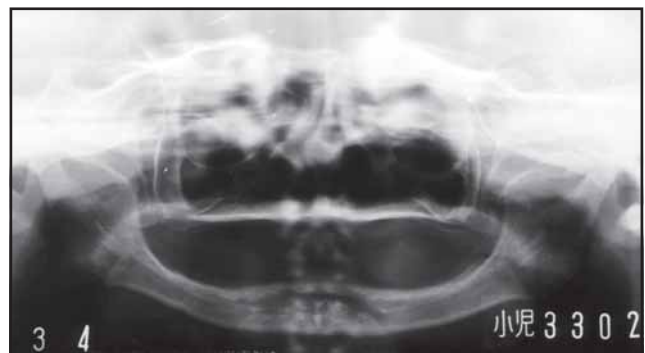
Panoramic radiograph revealed complete absence of both the primary and permanent teeth.
